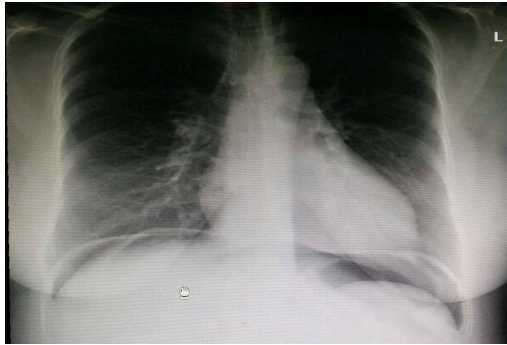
An Erect Chest X-ray Revealed Gas under Diaphragm.
